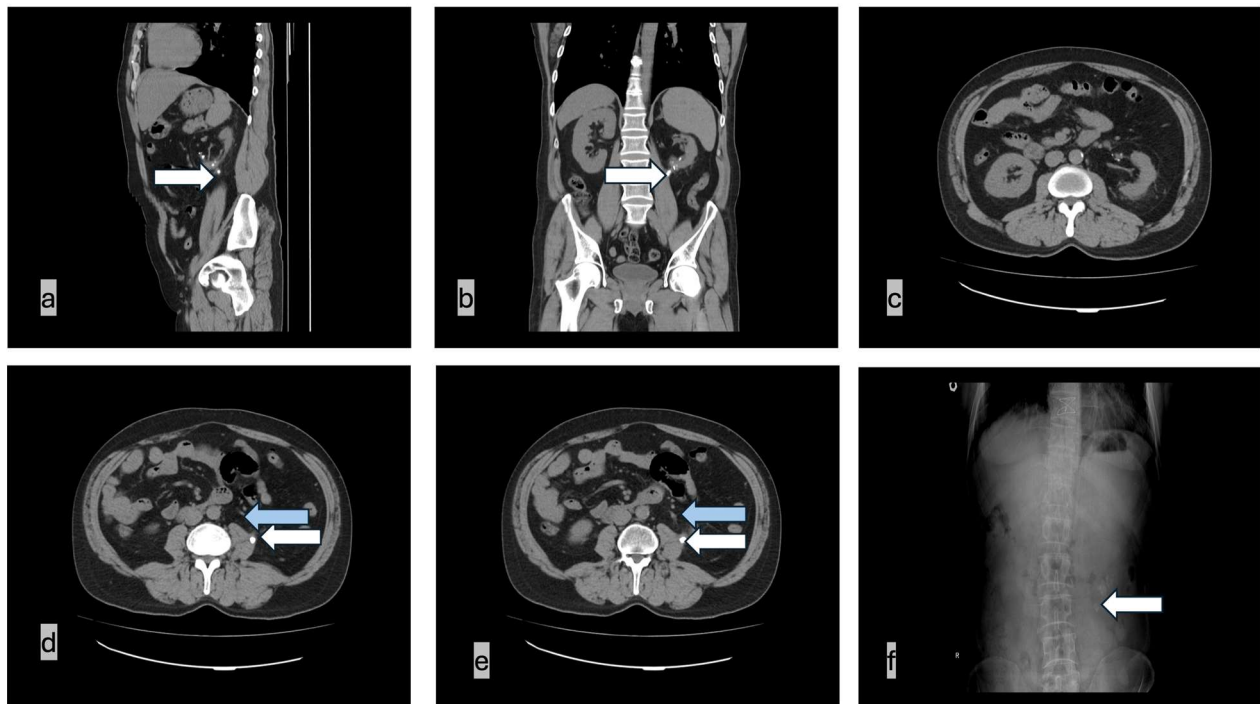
In CT imaging, the extrarenal stone (indicated by a white arrow) is seen lateral of the psoas major muscle, along with the course of the ureter (indicated by a blue arrow). a: Sagittal view (CT), b: Coronal view (CT), c, d, e: Axial views, f: Direct urinary system radiograph.
